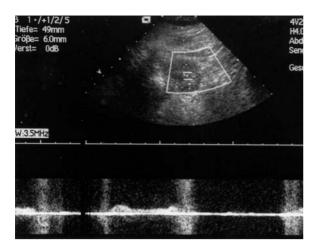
Imaging of complications after renal biopsy. Color Doppler sonography depicted an area with atypical colour signals and color aliasing suspicious for an arteriovenous fistula. Duplex Doppler sonography trace confirms the shunt flow of a post biopsy arteriovenous fistula
